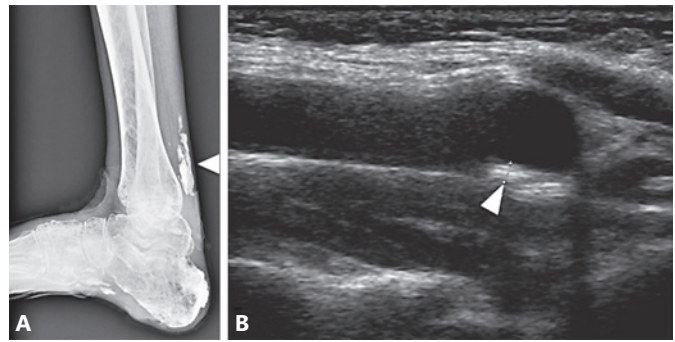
Radiographic findings of a newly identified Werner patient. A Calcification in the right Achilles tendon. B Atherosclerotic plaque in the left carotid artery.
